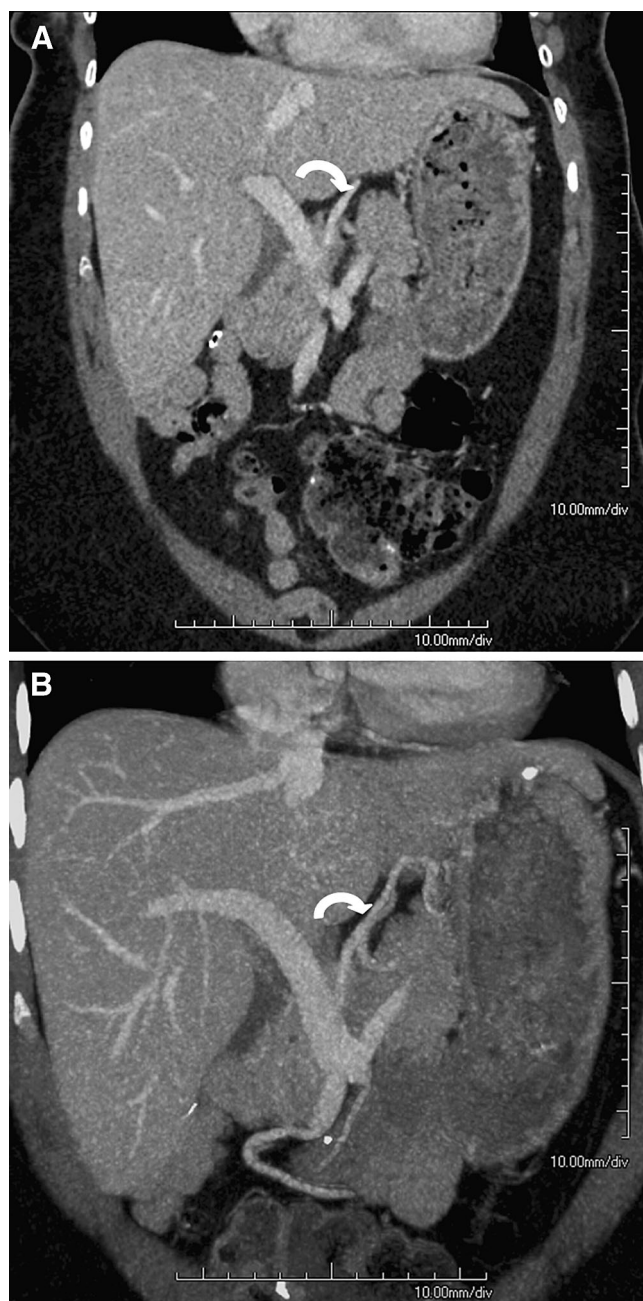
Intraparenchymal course of left gastric vein in a 61-year-old woman with suprasplenic circumportal pancreas and anteportal duct. A Coronal oblique CT image demonstrates the intraparenchymal course of the left gastric vein (*curved arrow*). B Coronal oblique Maximum Intensity Projection (MIP) CT image showing the left gastric vein (*curved arrow*) draining into the portal vein.
